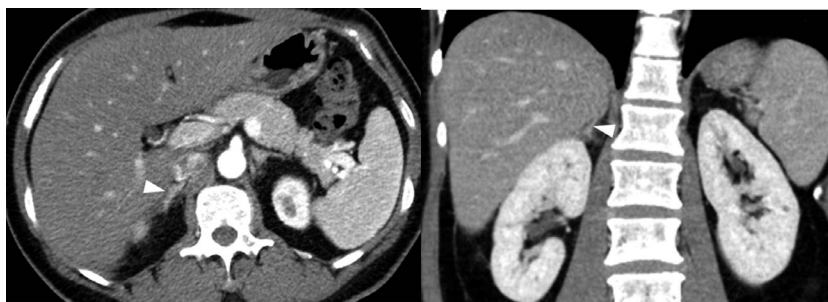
Postoperative contrast-enhanced CT shows the remaining adrenal gland (arrowhead).
